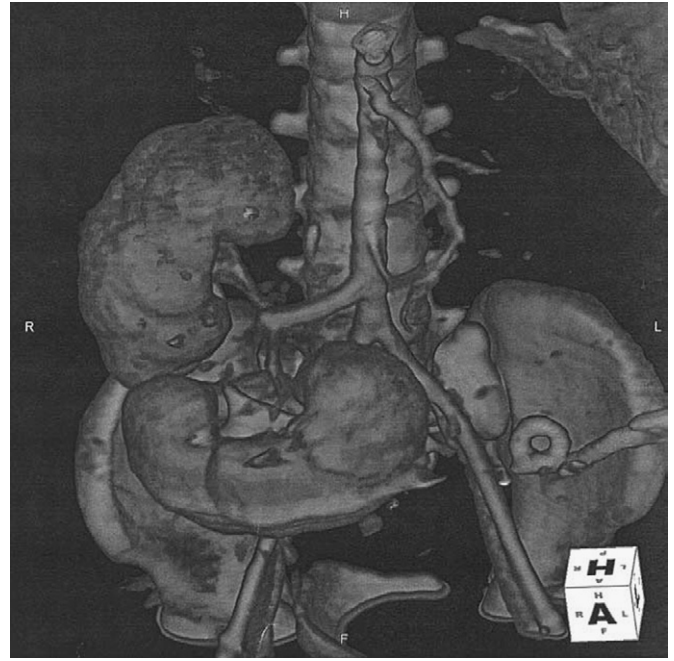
Electron beam computed tomography of transplanted kidney. (From Talisetti A, Jelnin V, Ruiz C, et al: Electron beam CT scan is a valuable and safe imaging tool for the pediatric surgical patient. *J Pediatr Surg* 2004;39:1859–1862.)
